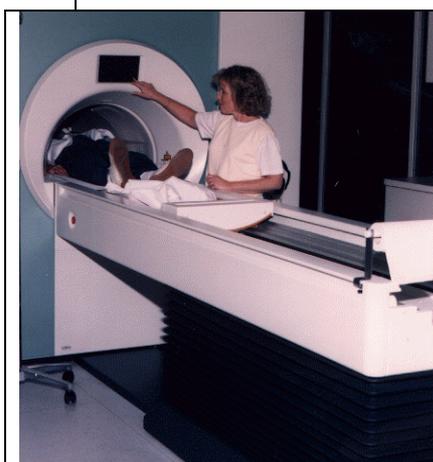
Computed tomography scanner.
